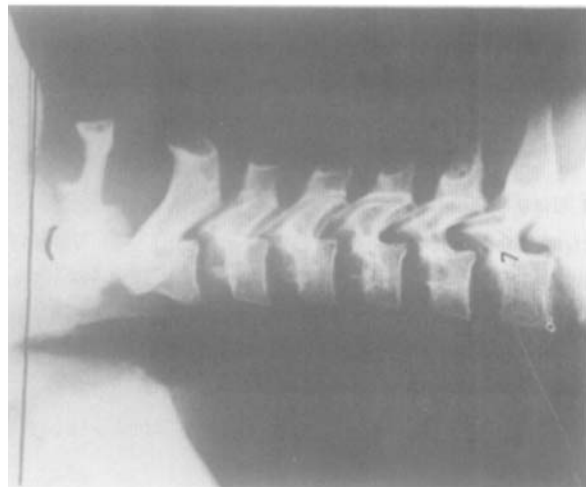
a. Lateral radiograph soon after distraction commenced. Note the distance between the dens and McGregor's line.
